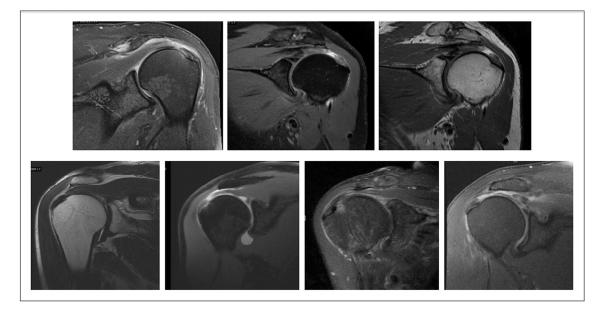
Magnetic resonance images showing transtendinous tears of the supraspinatus tendon. One should note the intact supraspinatus footprint with the remaining tendon retracted medially.
